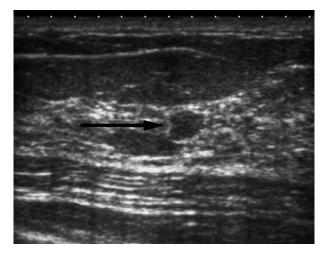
Asymptomatic 52-year-old woman. Sonogram shows a 7mm solid-type mass (arrow) with a round shape and microlobulated margins, categorized as BI-RADS 4b. Core needle biopsy showed intraductal papilloma. Surgical excision revealed a papilloma containing ductal carcinoma in situ.
